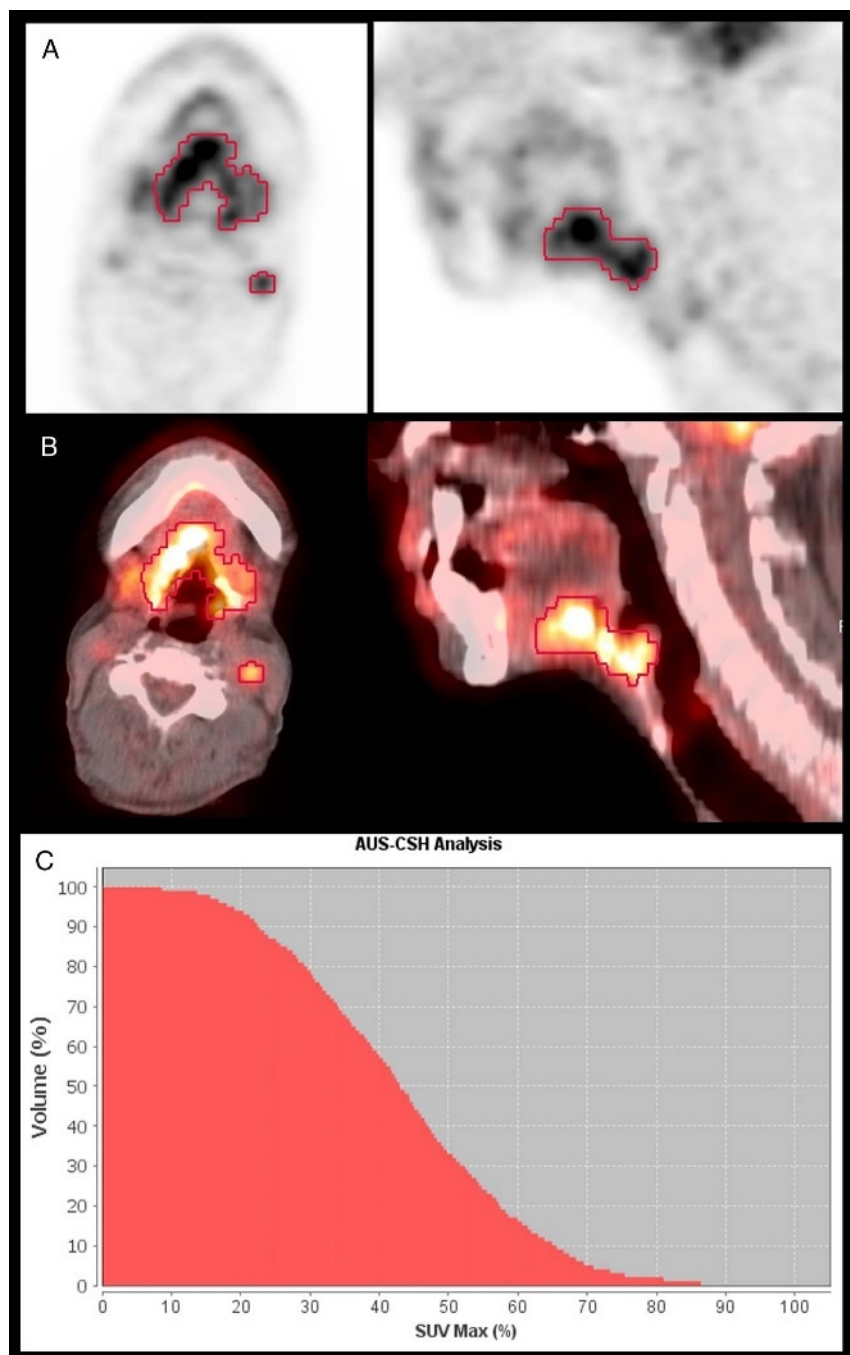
A 54-year-old woman with HPV-positive base of the tongue SCC stage IVa (T4a N2b M0). Axial and sagittal PET (A), axial and sagittal fused PET/CT (B), and axial and sagittal PET/CT images demonstrate intense FDG-avid primary tumor, and left level IIb lymph nodes, with the highest SUV_{max} of 7.7, MTV_{Total} of 65.2 mL, and TLG_{Total} of 619.7 g, by gradient-based segmentation. The calculated AUC-CSH index was 0.43 (C). Patient underwent chemoradiation therapy developing locoregional recurrence 15 months later.
